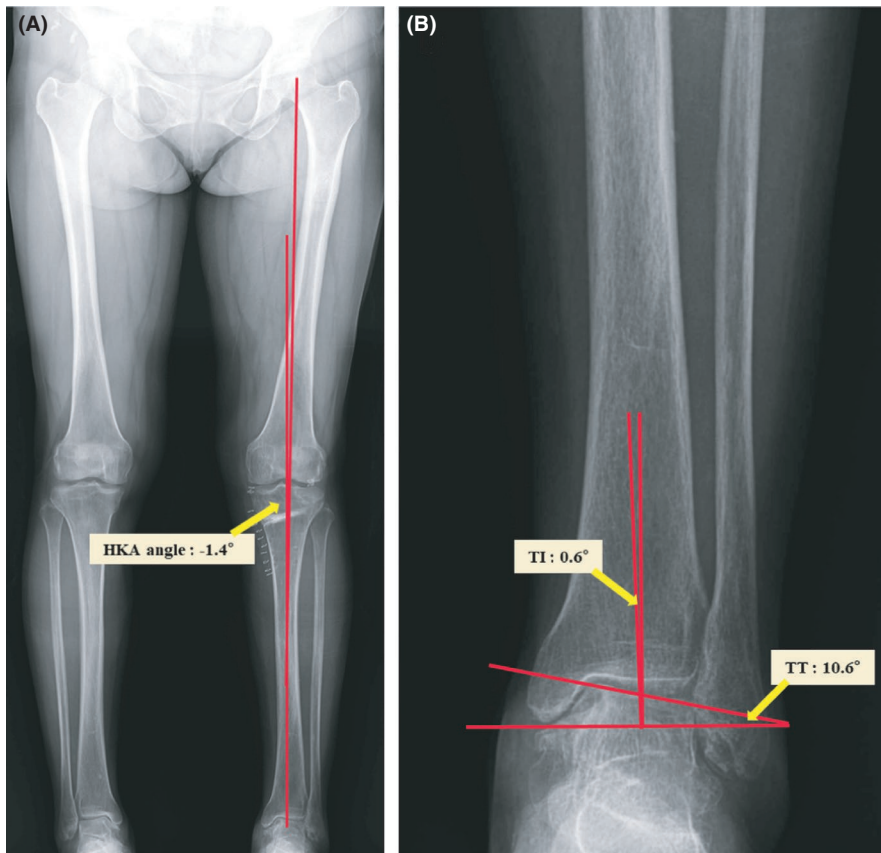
One year after high tibial osteotomy (HTO). Whole leg radiographs of a 59-y-old woman in the standing position. A, hip-knee-ankle (HKA) angle. B, talar tilt (TT) and tibial inclination (TI)
